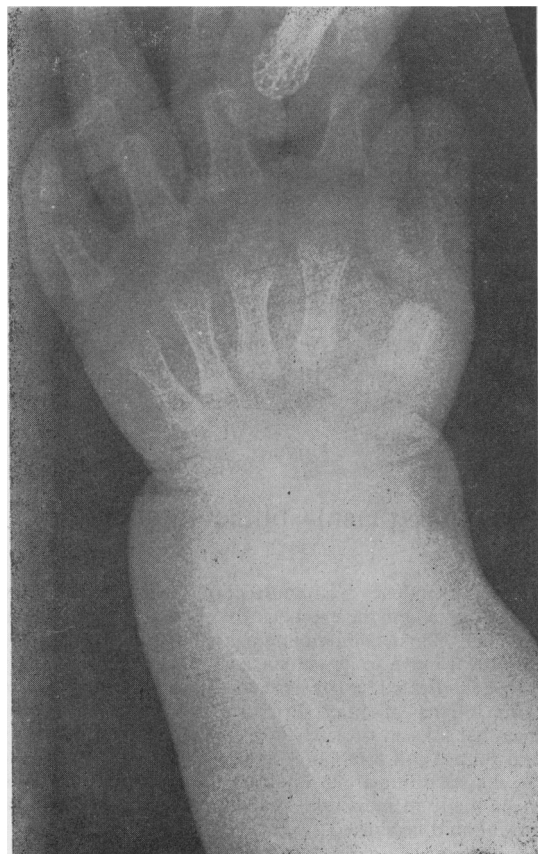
Case 2. X-ray of right wrist showing severe bone rarefaction with marked cupping of distal radial and ulnar metaphyses.
